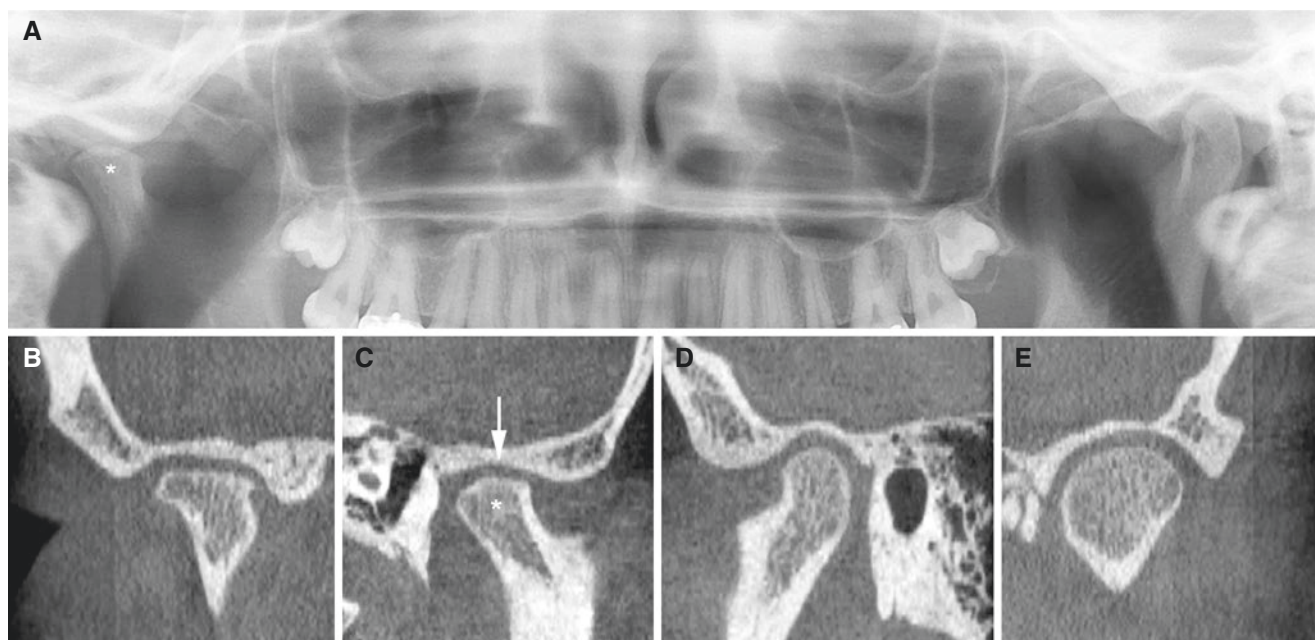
Juvenile idiopathic arthritis; 17-year-old female with variable jaw pain and mouth-opening problems. (A) Panoramic view and (B) oblique coronal and (C) oblique sagittal CBCT images show abnormal
